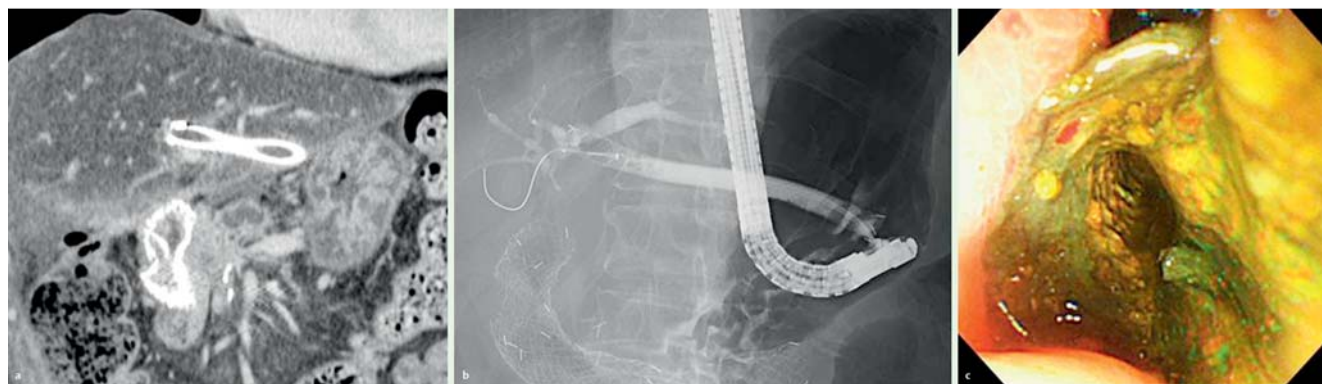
a Computed tomography showing a duodenal stent in the malignant duodenal stenosis and a biliary stent placed from the left intrahepatic bile duct to the stomach. a. Fluoroscopic image at the time of reintervention. The inside of the stent was cleaned using a retrieval balloon catheter over a guidewire. b. Endoscopic image at the time of reintervention. A large amount of sludge was removed from the inside of the stent.
